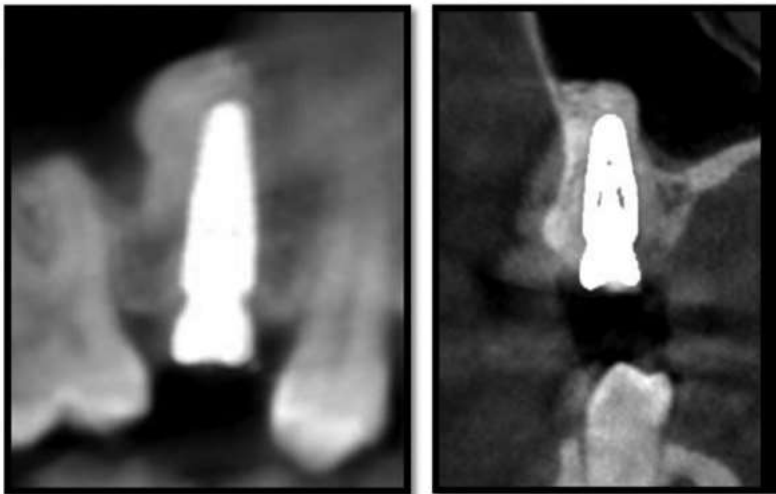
Case 3 immediately postoperative CBCT
